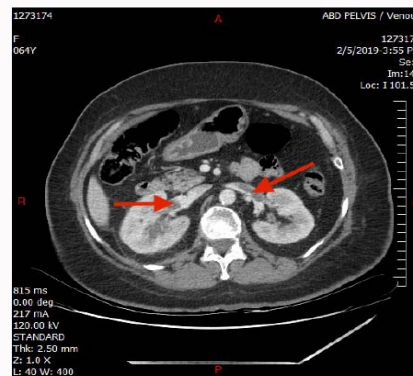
Computed tomography axial view showing subtotal occlusion of bilateral renal veins (arrows).
